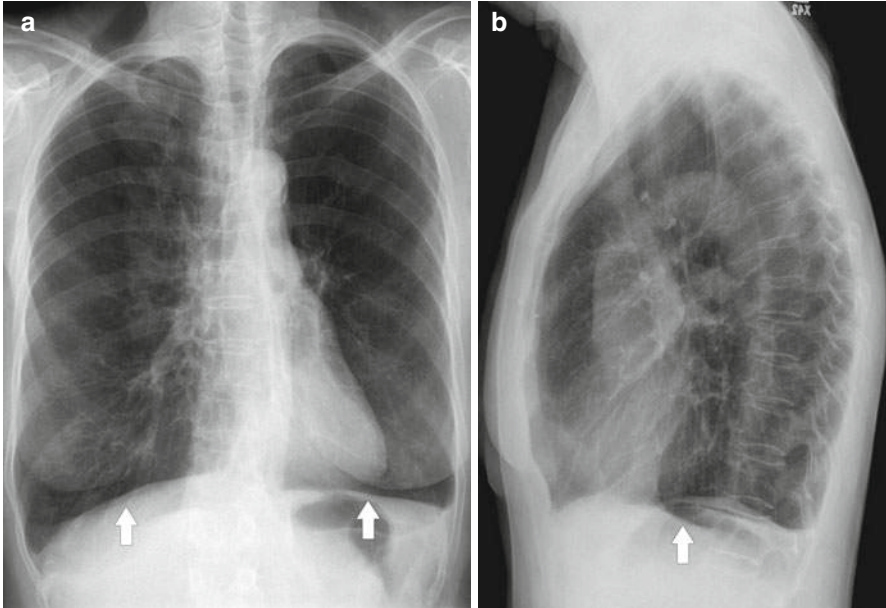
Emphysema. Chest X-ray posteroanterior (a) and lateral (b) views show hyperinflated lungs and flattened diaphragm (arrows)
